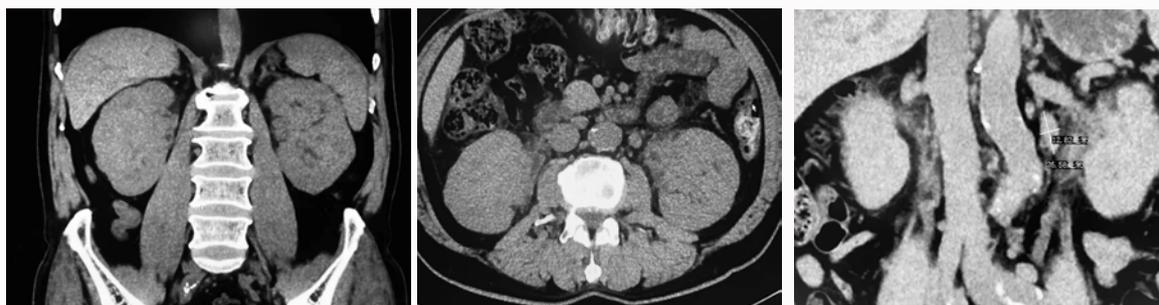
Abdominal CT scan of the patient. CT showed both kidneys enlarged, soft tissue shadow of both renal pelvises, multiple lymph nodes in the hilar region, retroperitoneum, and bilateral groin.
